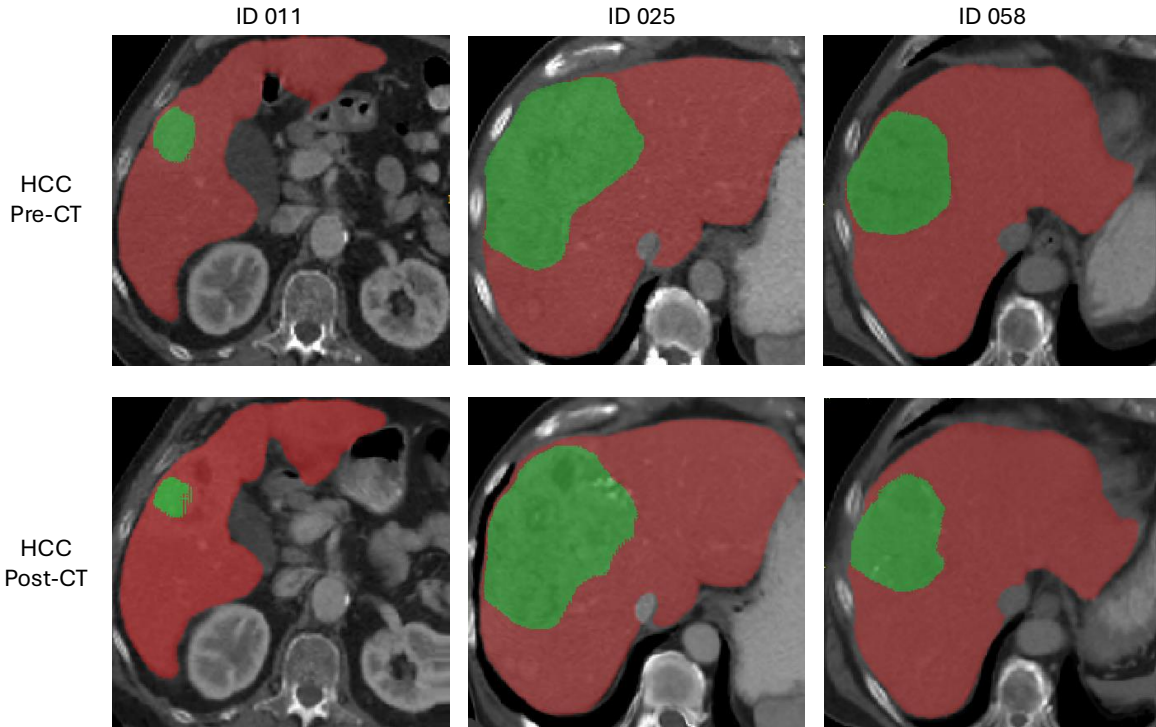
Example of HCC-TACE-Seg dataset. The first row shows HCC Pre-CT images, and the second row shows HCC Post-CT images. The red mask represents the liver, while the green mask represents the HCC tumor.
